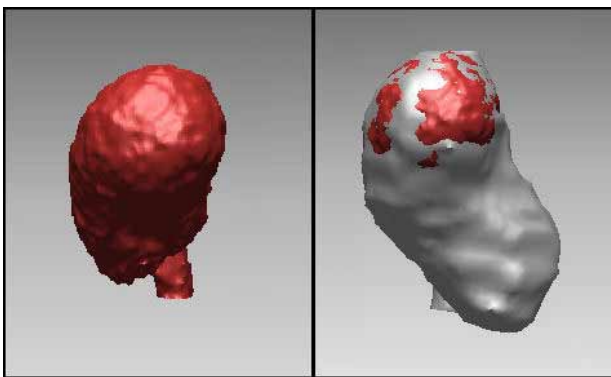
Surface renderings of giant fusiform basilar artery aneurysm. Left: luminal surface (in red) determined from CE-MRA; and Right: luminal surface from CE-MRA (red) and thrombus volume (gray) from steady state MRI.
